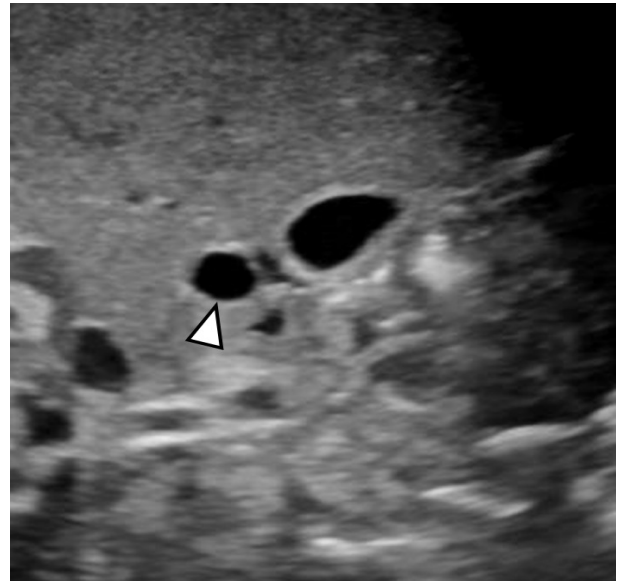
Abdominal ultrasound showed a cystic structure adjacent to the gall bladder and common bile duct representing a choledochal cyst (arrow).
